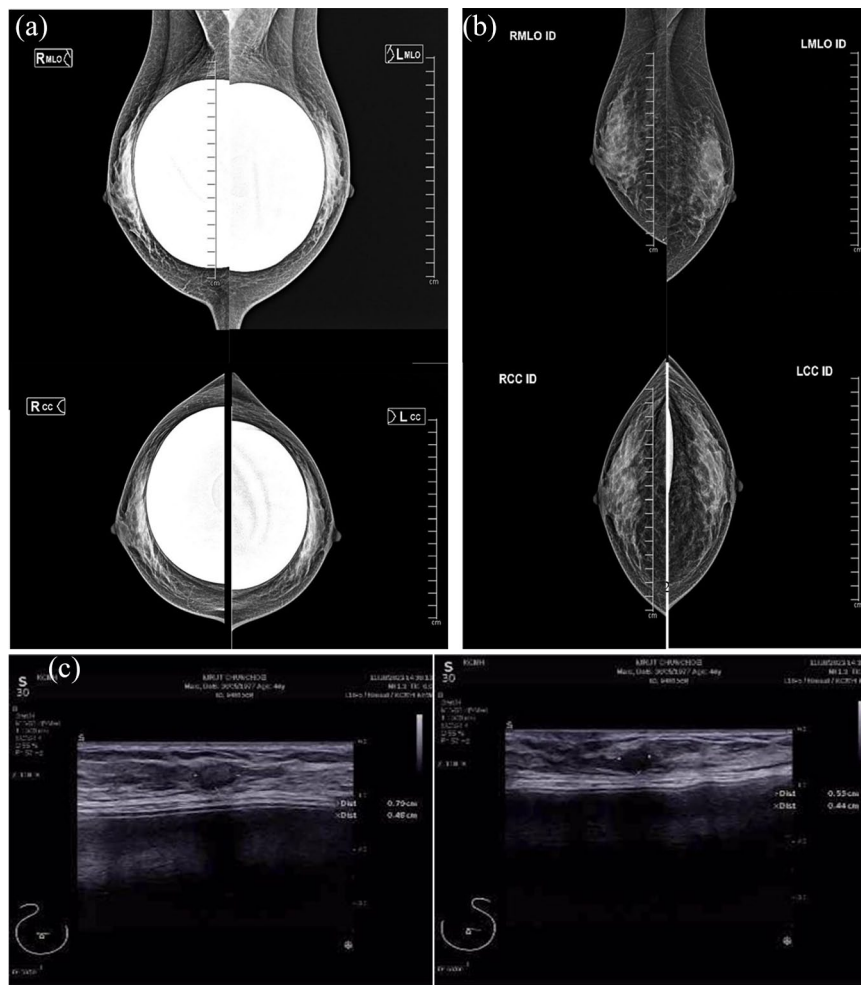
A case of 47-year-old TGW on estradiol therapy for 15 years, presenting with a palpable right breast lump. Screening mammogram shows heterogeneously dense fibrogranular tissue: (a) Mediolateral oblique and craniocaudal view demonstrates bilateral subpectoral prosthesis. (b) Implant displacement view on the diagnostic mammogram demonstrates a few calcifications at the right nipple are observed, benign. (c) Additional ultrasound shows a few circumscribed hypoechoic nodules without vascularity in both breasts.
